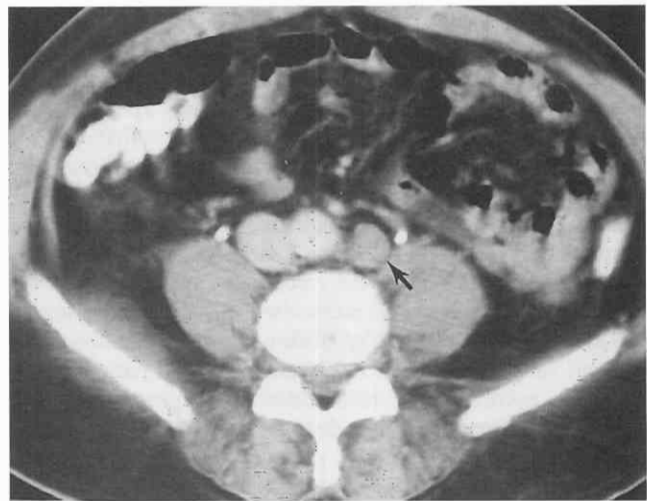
Prostate cancer metastatic to retroperitoneal lymph nodes. Contrast-enhanced axial CT image demonstrates a large lymph node metastasis in the left para-aortic region (arrow) of a 60-year-old man. This lymph node can be followed on serial CT scans once hormonal therapy is instituted.
